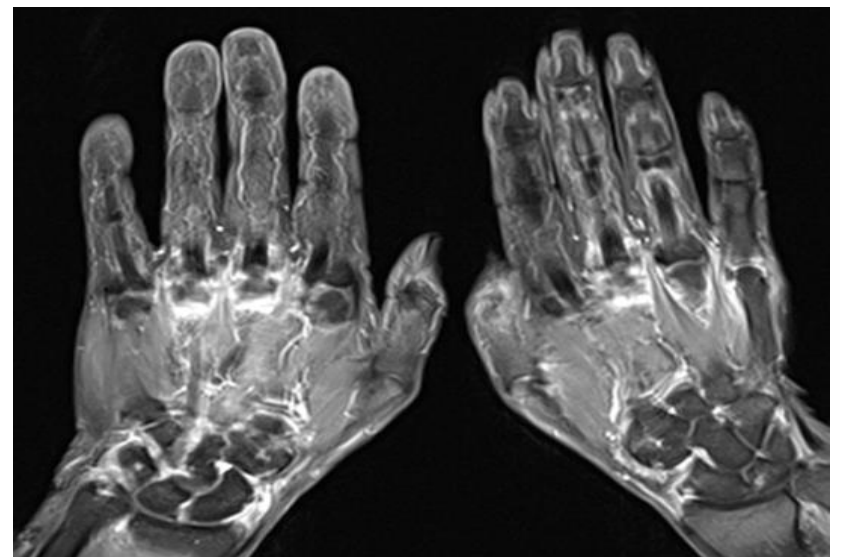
MRI both hands post contrast showed relatively symmetry, thickened and enhancing tendons of the of the hands bilaterally with involvement of the carpal, carpo-metacarpals, and metacarpo-phalangeal joints.
